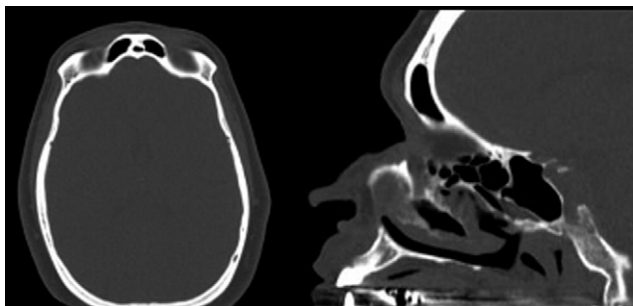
CT images in axial (left) and sagittal (right) planes. These are used to assess the anterior-to-posterior dimensions of the frontal sinus when planning for a trephination.
